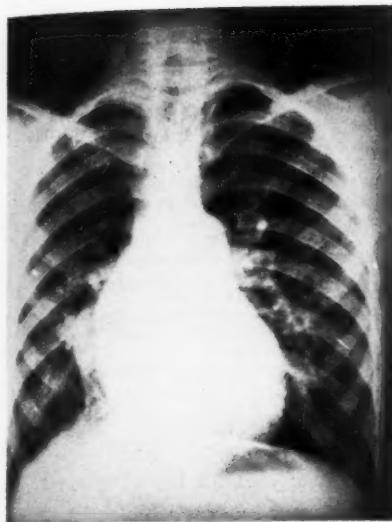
Case II. Postero-anterior roentgenogram of the chest showing enlargement of the lung roots and of the undivided segment of the pulmonary artery. The right side of the heart is prominent. Paralleling the right cardiac border and extending into the right cardiophrenic angle is an anomalous venous trunk.
